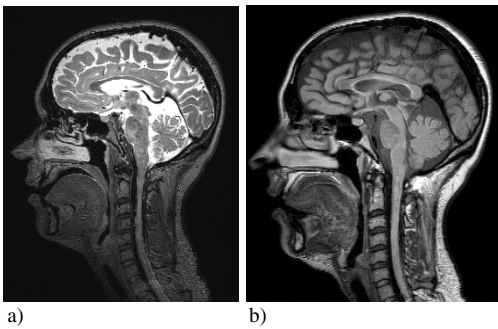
Images from 3D, high resolution, isotropic MS protocol: T2 (a) and FLAIR (b).
